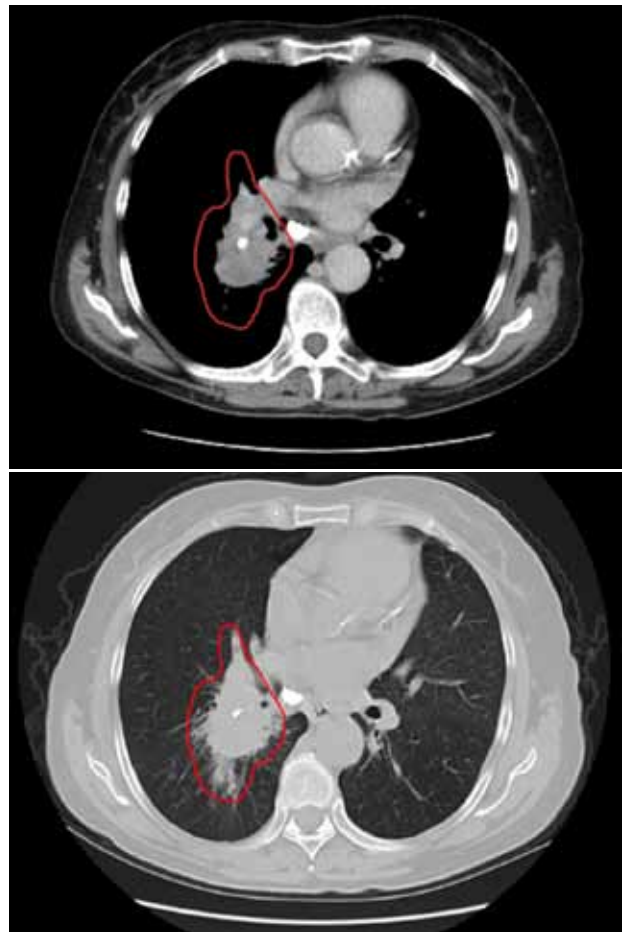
A positive pulmonary nodule found on PET CT.
